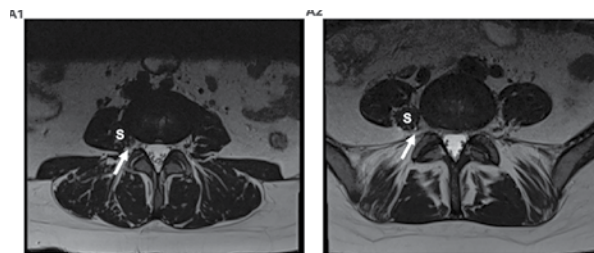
Lumbar MRI demonstrates the occluded kissing stent encroaching spinal nerve roots at L3-L4 and L4-L5 levels (arrows) on the right side.
